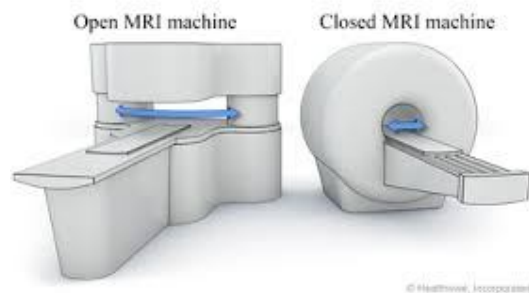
open and close MRI machines
